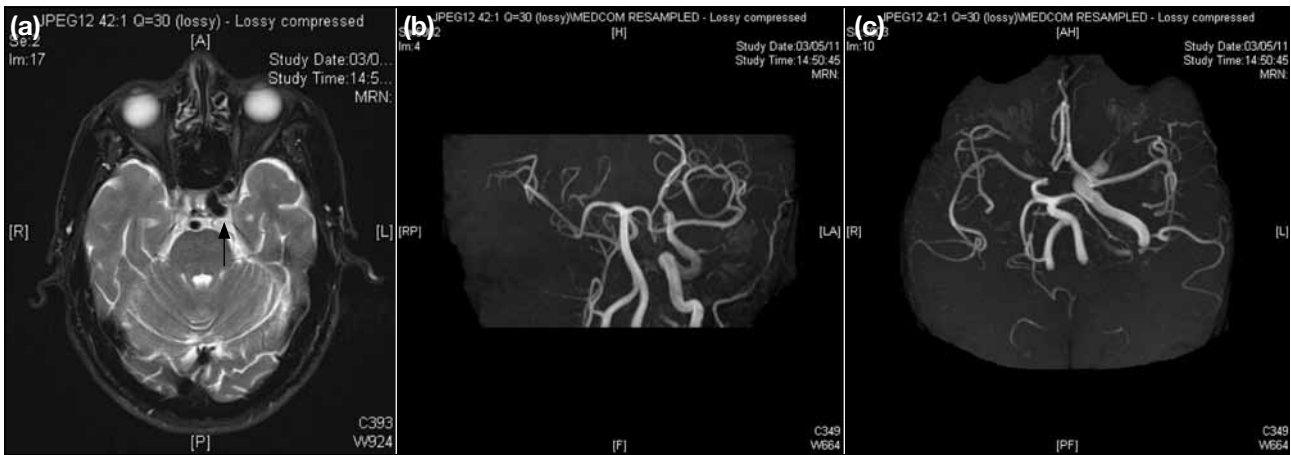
(a) A T2-weighted magnetic resonance image showing signal void (arrow) representing the left internal carotid artery, and (b, c) magnetic resonance angiography showing absence of the right internal carotid artery with the right middle cerebral artery supplied by the right posterior cerebral artery.
